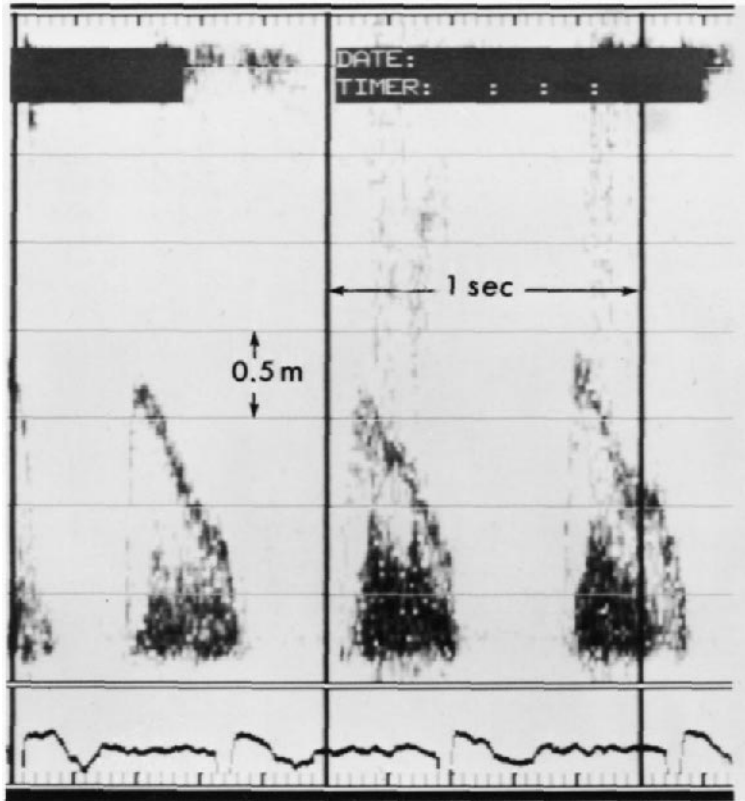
Continuous-wave Doppler tracing across a stenotic mitral valve orifice due to mitral annular calcium. Peak diastolic gradient = 12 mm Hg. Pressure halftime = 200 ms. Mitral valve area = 1.1 cm².
